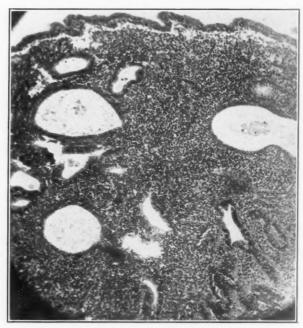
Case 10. W. U. Secondary amenorrhea (x-ray castration). Experimental production of cystic and glandular hyperplasia of the endometrium. 700,000 R. U. of progynon-B given.
